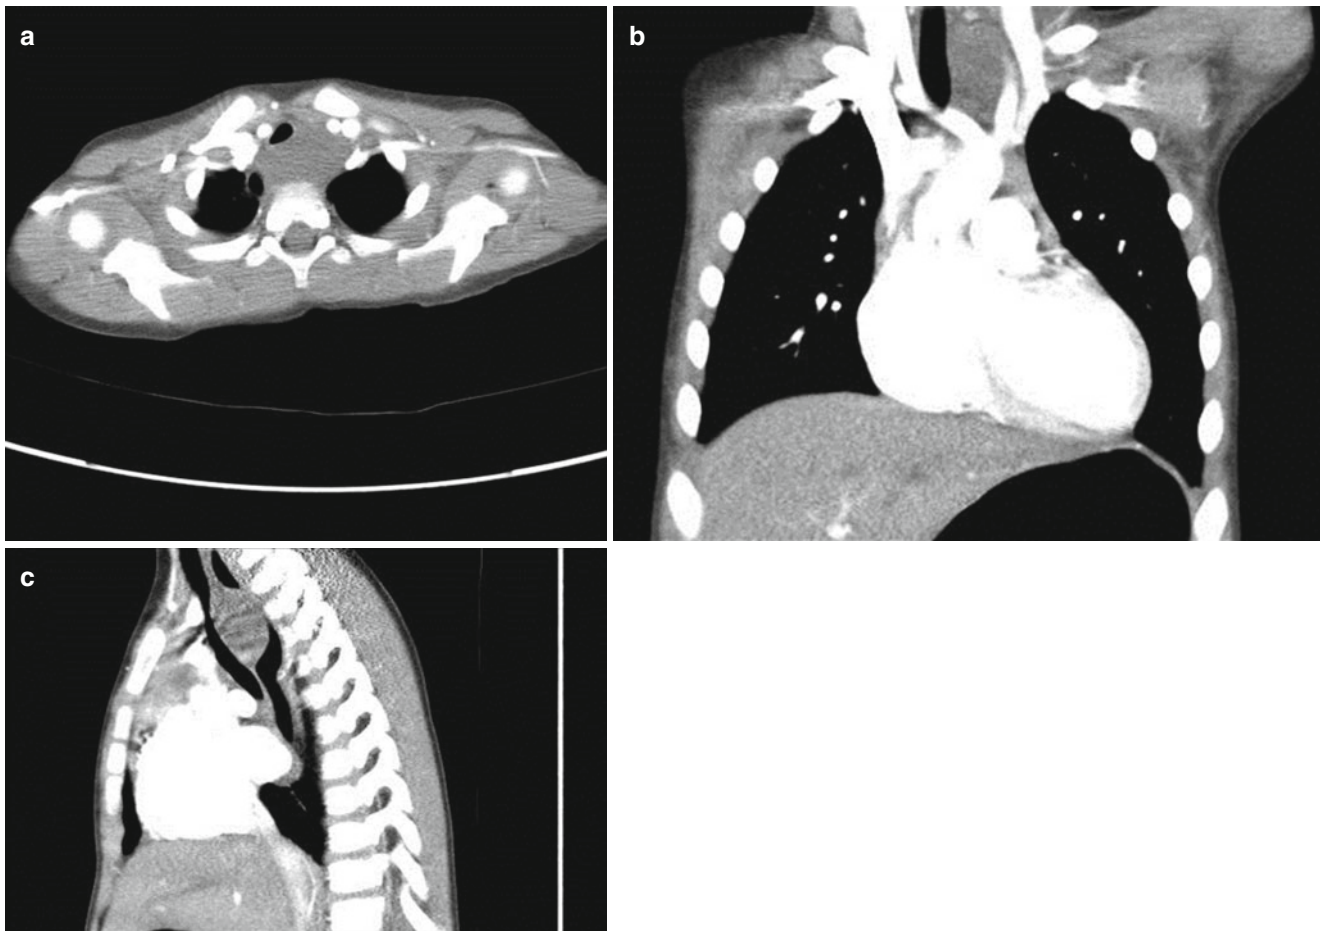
(a) Axial, (b) coronal, and (c) sagittal view. A 2 year old boy presented with chronic cough and mild dysphagia. CT scan revealed a cystic mass in the superior mediastinum partially compressing the trachea anteriorly and the esophagus posteriorly. The patient underwent stepwise
